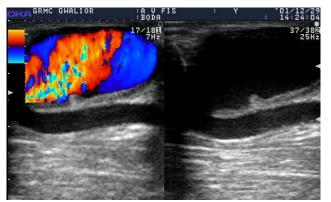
Colour duplex sonography of brachial artery pseudoaneurysm: shows yingyang pattern caused by swirling of blood in the pseudoaneurysm cavity.
